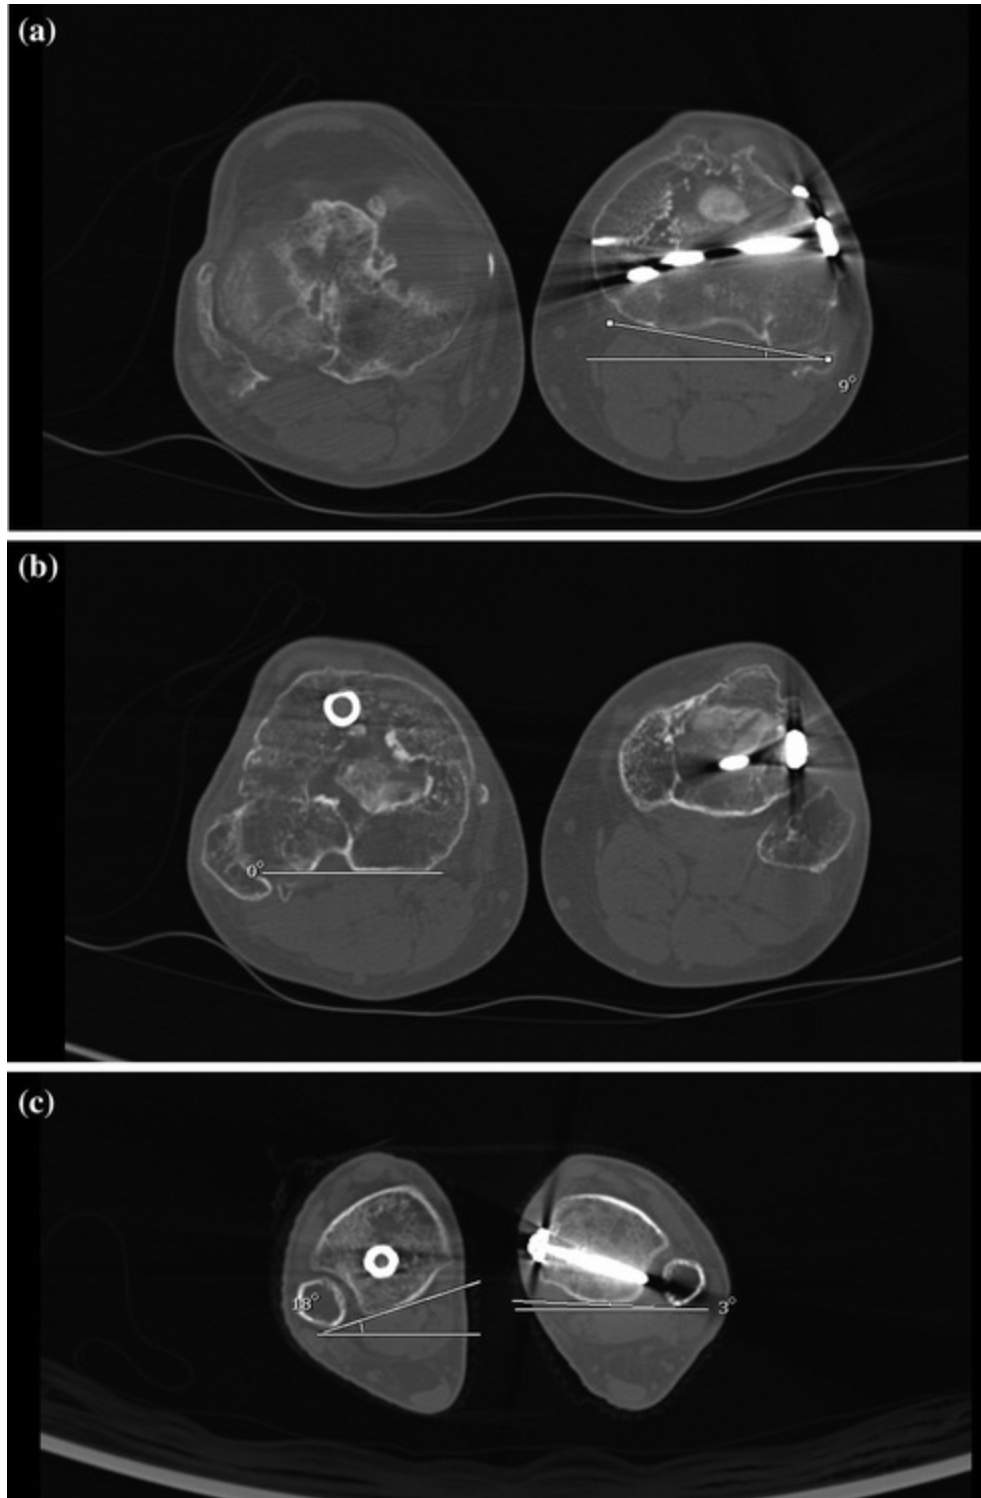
(a–c. Computed tomography scan images showing how to measure malrotation of left tibia— 24° internal rotation compared to *right side*)
